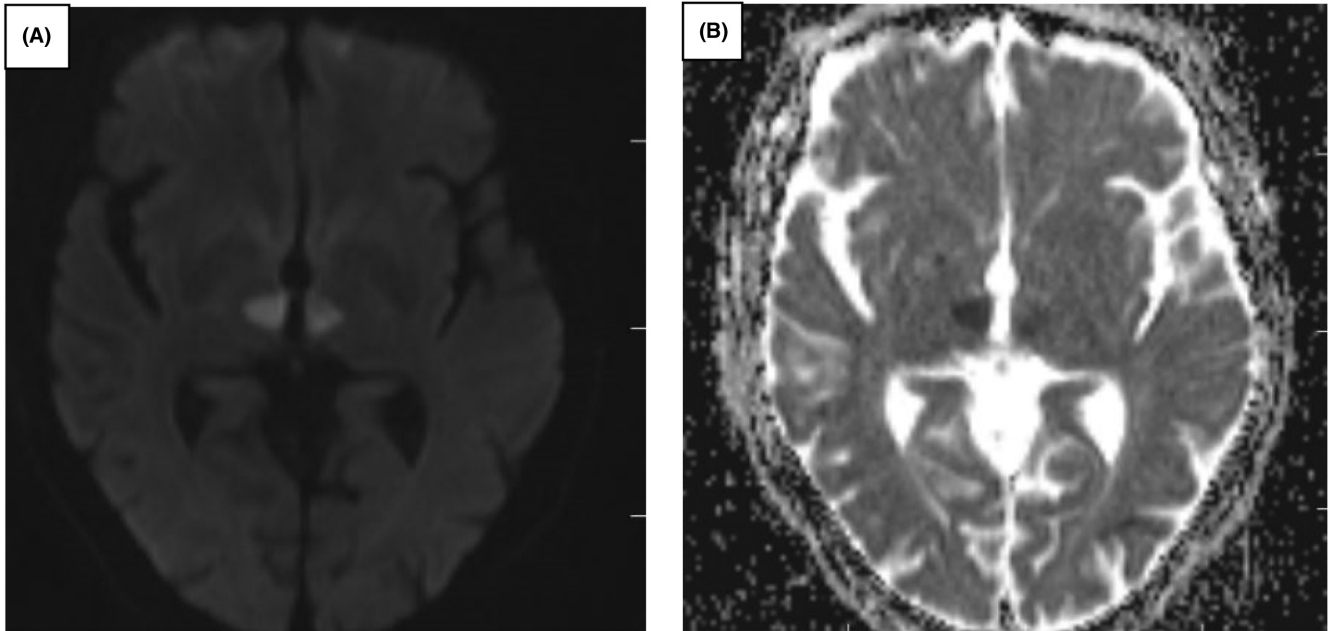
(A) Cerebral DWI showed hyperintensity in bilateral thalamus. (B) ADC sequence showed hypointensity at both thalamus; this is consistent with acute bilateral thalamic infarction.
